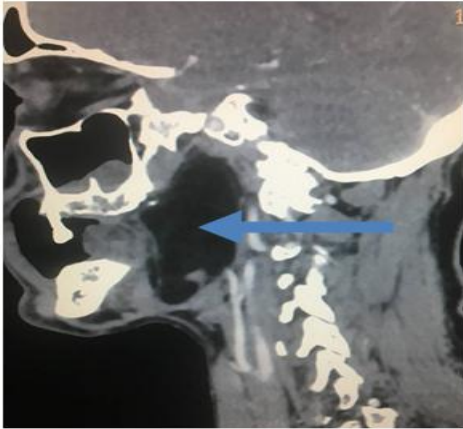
Saggital post contrast CT image of the patient reveals fat density lesion (arrow) in sublingual area extending into submandibular and parapharyngeal space.
